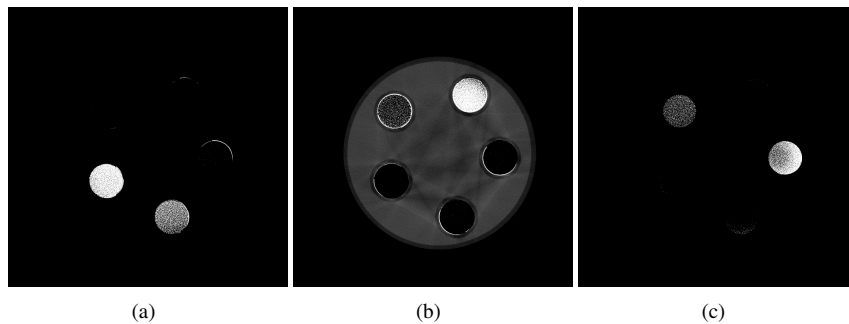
Decomposition in three basis materials of the same CT slice recorded at 60 kV and at 180 kV, both using a 3 mm Al filter, showing the calculated volume fractions of the KBr solution (a), the PTA solution (b) and the $Pb(NO_3)_2$ solution (c). A threshold of 0.5 was applied for each image.
